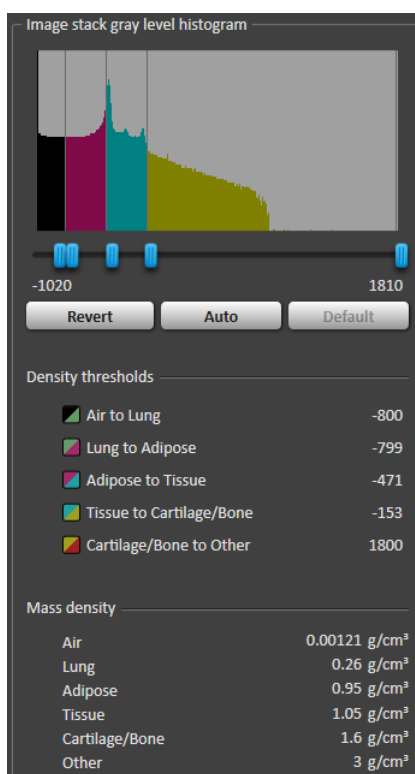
RayStation's (RaySearch Laboratories AB, Stockholm, Sweden) implementation for the generation of tissue specific HU-to-density curves for CBCT images.
